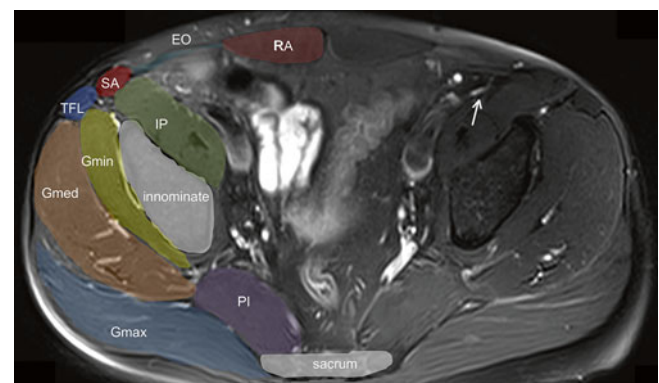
MRI showing the lateral femoral cutaneous nerve at the iliacus muscle (*white arrow*). *EO* external oblique muscle, *Gmax* gluteus maximus muscle, *Gmed* gluteus medius muscle, *Gmin* gluteus minimus, *IP* iliopsoas muscle, *PI* piriformis muscle, *RA* rectus abdominus muscle, *SA* sartorius muscle, *TFL* tensor fascia lata muscle. (Image courtesy of Andrea Trescot, MD)
